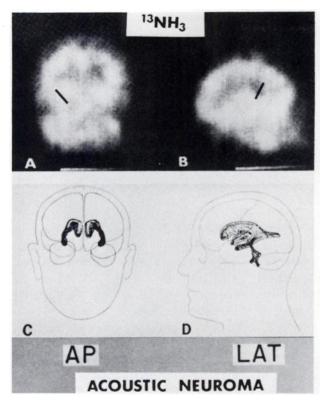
Positron scintigrams taken with ¹³NH₁₁ in 52-year-old woman with right acoustic neuroma. (A,B) Images smoothed once with nine-point running average. (C,D) Sketches showing positions of cerebral ventricles in AP and LAT projections.
